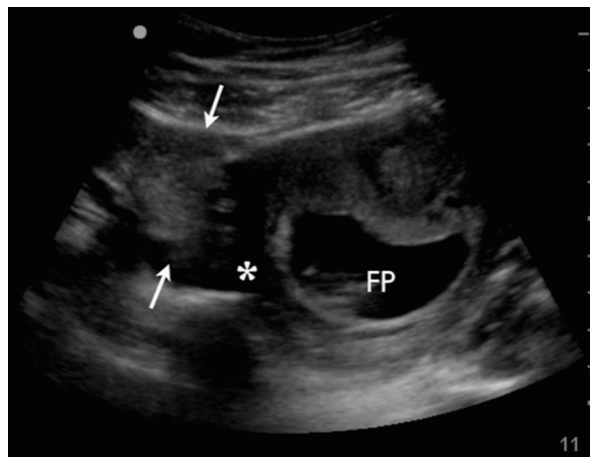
Transabdominal ultrasound shows the uterus with fetal pole (FP) and an enlarged ovary (arrows) with a small amount of free fluid (*) in the space between ovary and uterus.
